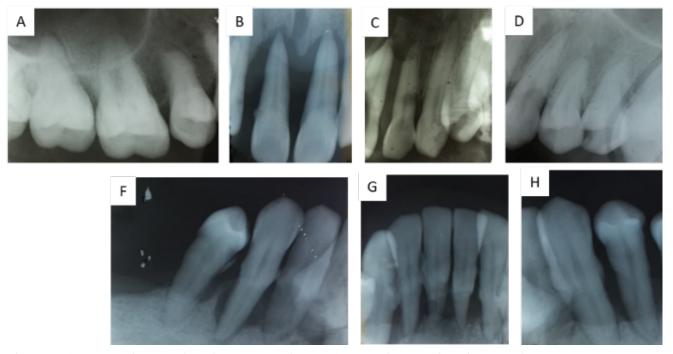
(A) X-ray image of teeth 17, 16, and 15; (B) X-ray image of teeth 11, and 21; (C) X-ray image of teeth 2. 2, 2. 3, and 24; (D) X-ray image of teeth 23, 24, and 25; (E) X-ray image teeth 25, 26, and 27; (F) X-ray image of teeth 44, 43, and 42; (G) X-ray image of teeth 42, 41, 31, and 32; (H) X-ray image of teeth 33, 34, and 35.
